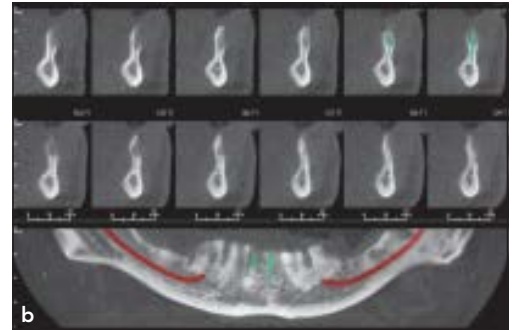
CBCT image showing cross-section of well-healed, rounded alveolar ridge.
